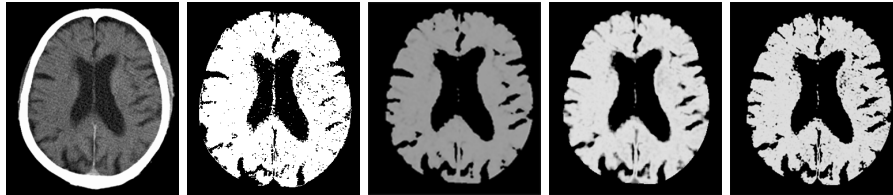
CT brain segmentation. (a) Original axial CT slice. (b) Simple thresholding of the original data. (c) Brain matter from Bayesian classification. (d) Brain matter from PDI method. (e) Brain matter from EM method.
